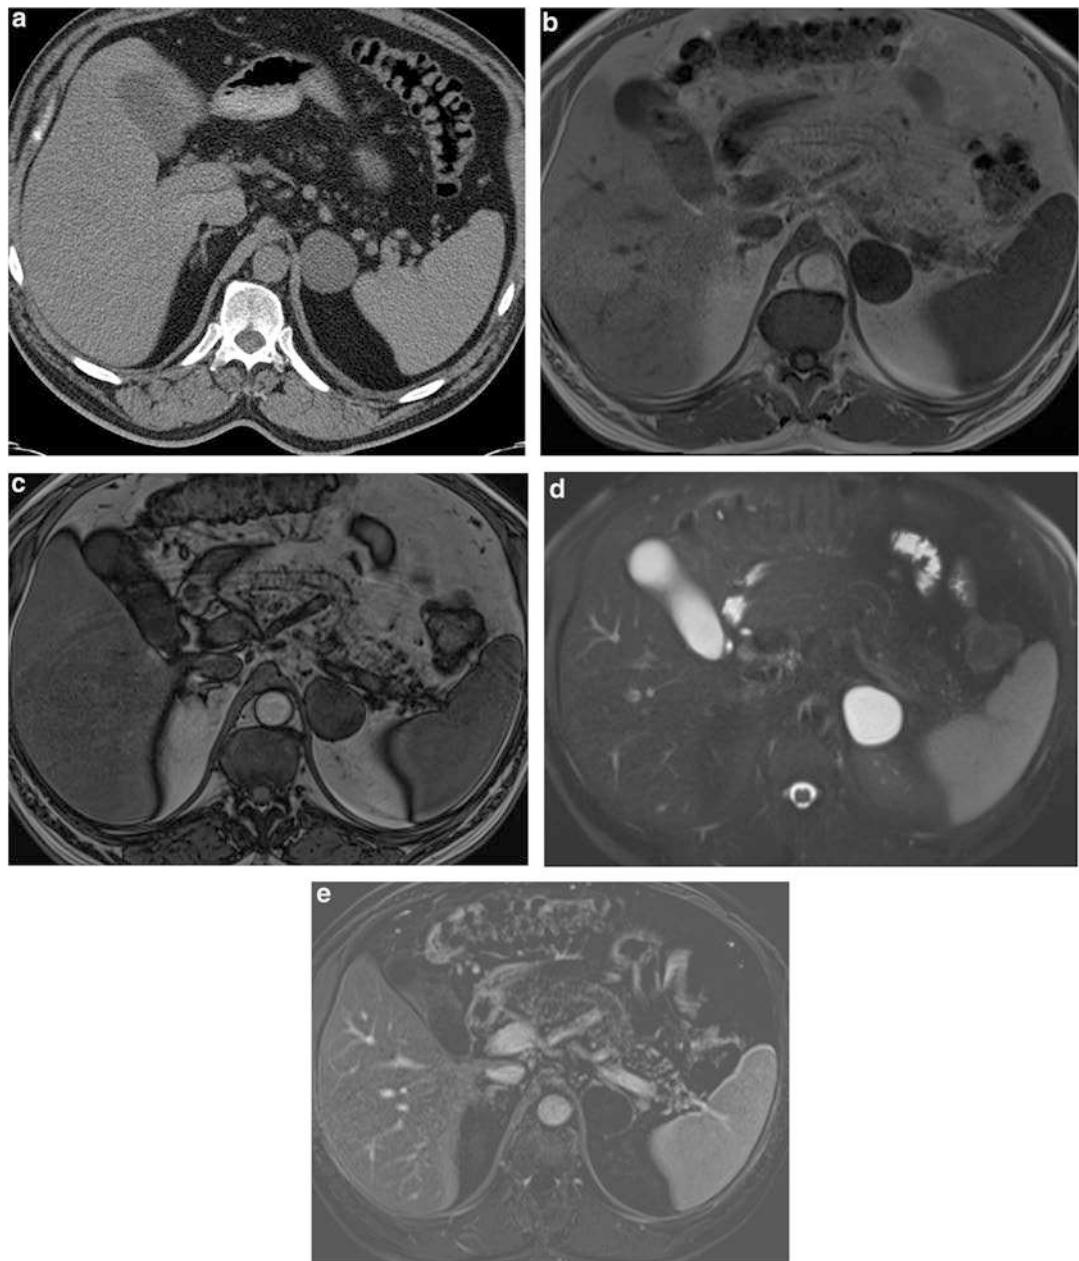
Adrenal cyst appearance on unenhanced CT and various MRI sequences. (a) 4.7 cm homogeneous hypodense left adrenal mass that measures between 16 and 20 Housefield units on unenhanced CT. (b) In-phase T1w MRI without contrast of the left adrenal mass. (c)
